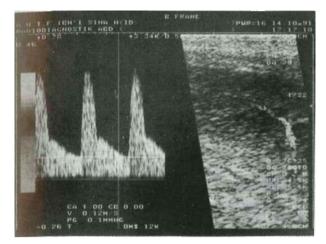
Doppler sonogram of a patient with penile venous leakage. Spectral wafeform in the right cavernosal artery 15 min after the injection of 60mg papaverine shows in normal peak-systolic velocity (approximately 65 cm/sec) but high end-diastolic velocity (approximately 12 cm/sec).
